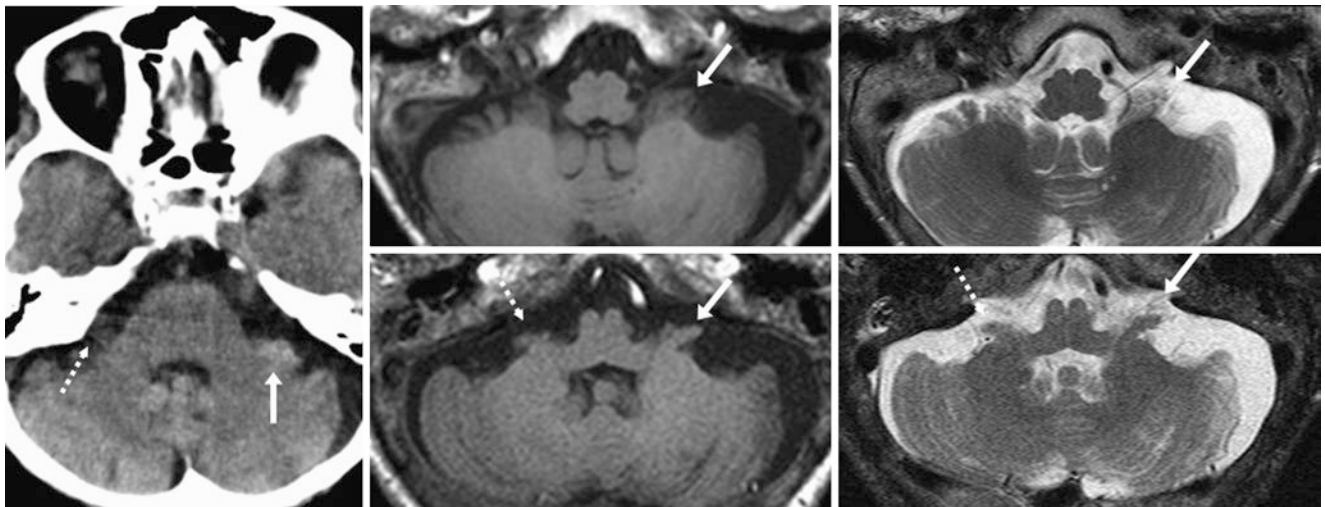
The patient was a 70 year old with visual deficit (negative 1.5 T MRI). On NECT (*left*), there was a hyperdense pseudomass of the left CPA (*arrows*), which was shown to be the left cerebellar flocculus
